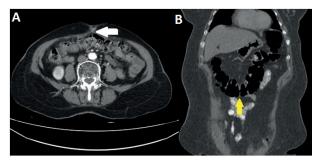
Axial (A) and coronal (B) computed tomography images of patients who have previously undergone umbilical hernioraphy. Transverse colon appears to adhere to the hernioraphy area.
